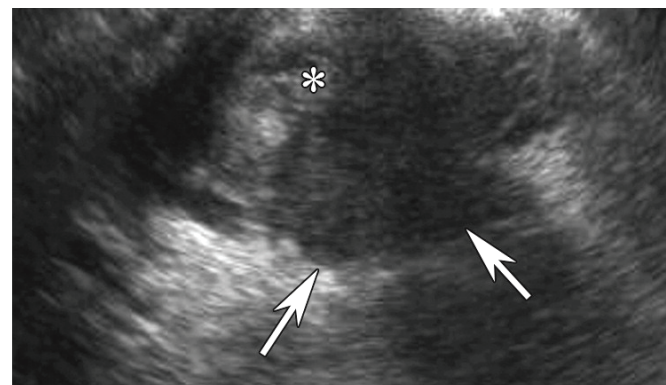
Coronal endovaginal ultrasound scan through the cervix in a case of endometriosis showing a hypoechoic mass centred in the Pouch of Douglas infiltrating the cervix posterolateral to the endocervical canal (*).
